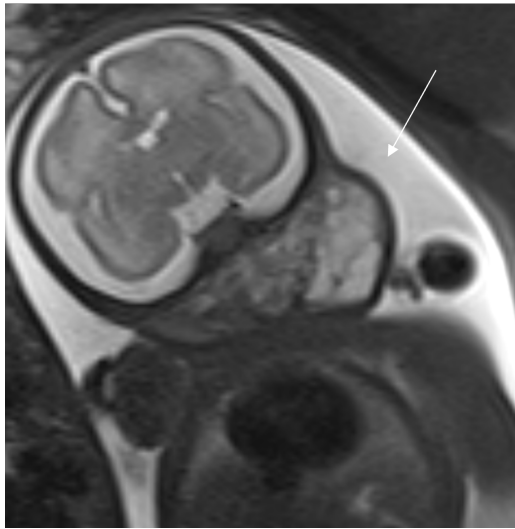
Fetal MRI images of Kaposiform lymphangiomatosis
